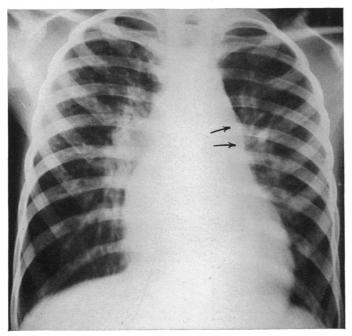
Case 3: Seven-foot roentgenogram prior to operation. Moderate cardiac enlargement. Prominence in region of pulmonary artery indicated by arrows. Increased markings in lung fields. Total transverse dimension of heart 9.8 cm. Internal diameter of chest 18.6 cm.
